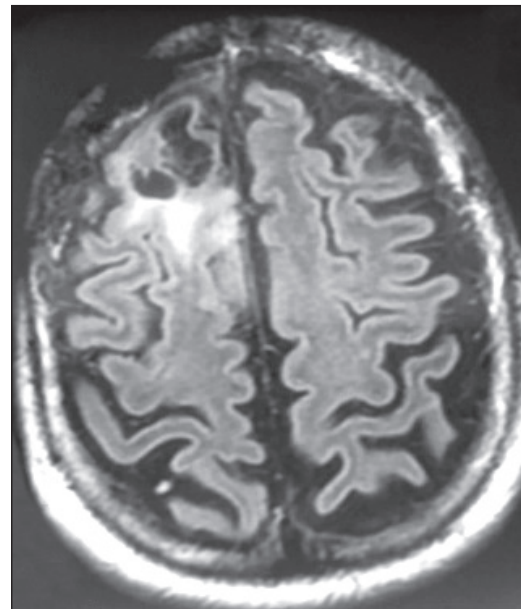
The FLAIR T2-weighted MRI from “Case 3” was performed on his 10-year control visit. MRI shows a right frontal mass measuring 1.5×2.2×1.9 cm. The patient refused surgery because he had no complaints. Note the right frontal craniotomy defect, which was performed for the primary tumor.
